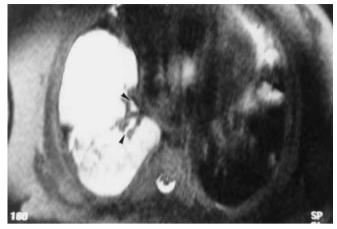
A 70-year-old man with mucinous "lobar" bronchioloalveolar carcinoma. Gadolinium-enhanced T1-weighted MR image shows a non-segmental pulmonary consolidation of the right lower lobe. Consolidation has low signal intensity and contains enhanced vessels (angiogram sign) and patent bronchi
